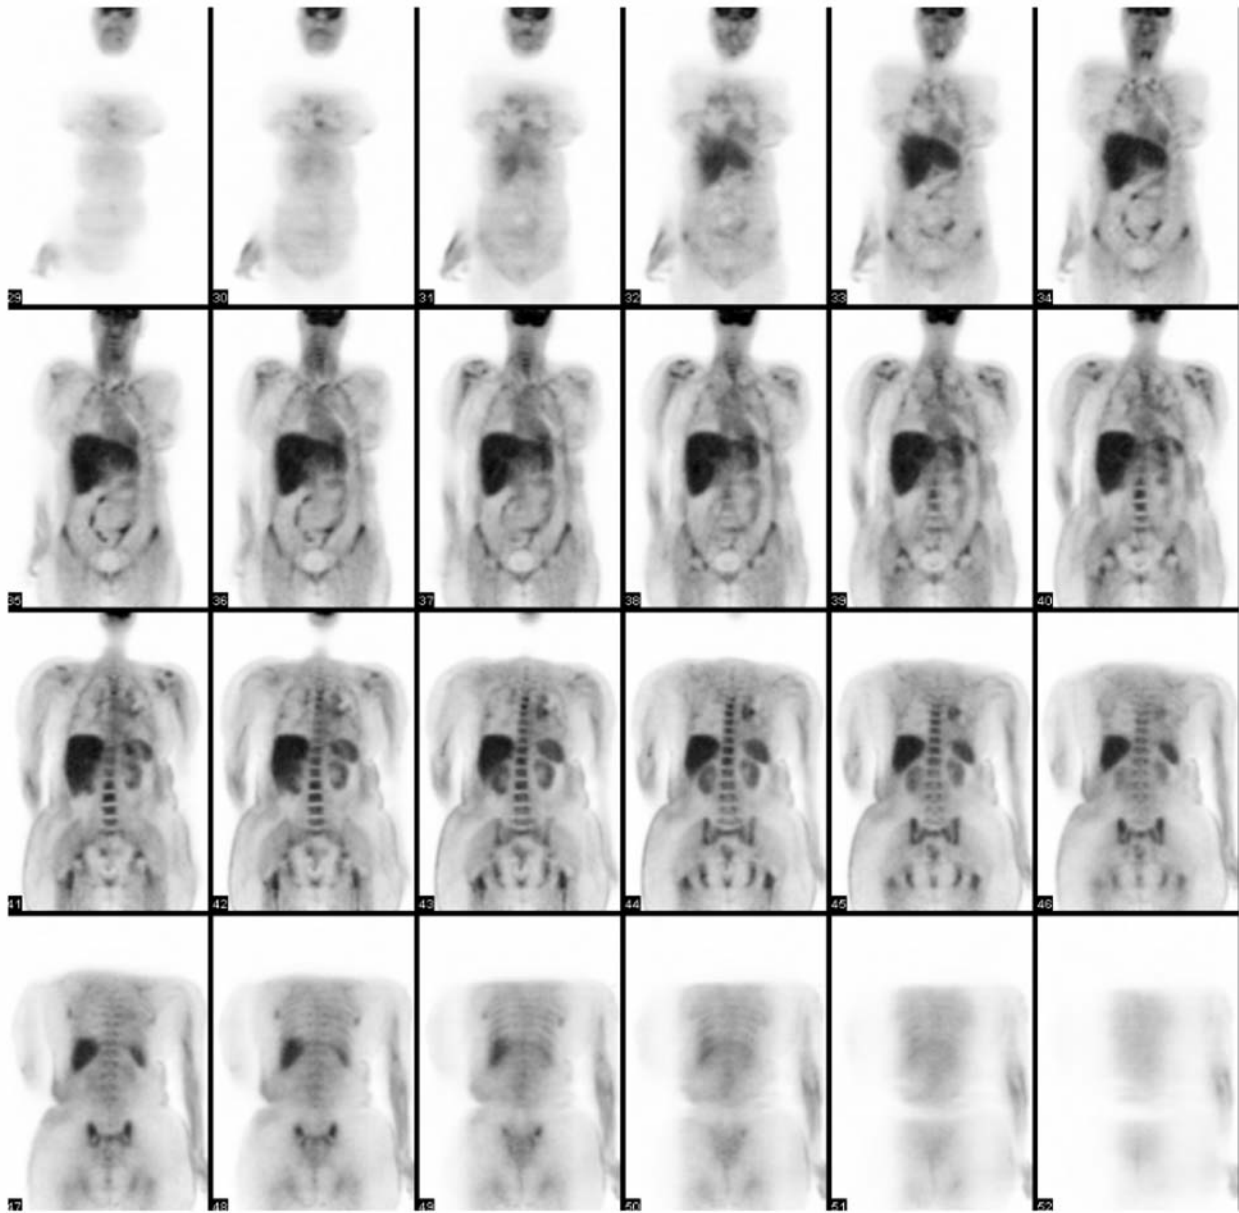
A repeat positron-emission tomography-computed tomography 21 days after the first dose of brentuximab revealed complete resolution of increased fluorodeoxy-glucose uptake.
